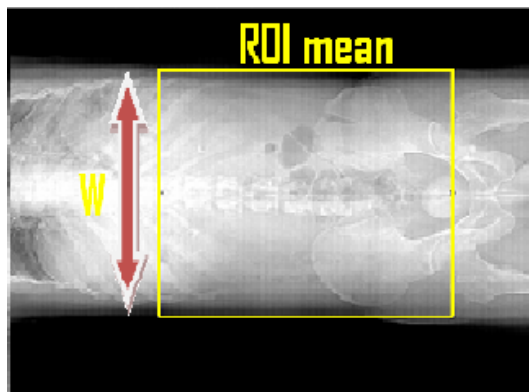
This figure shows the parameters which are used for scout attenuation area calculation. ROI mean is the average CT number of the pixels within the ROI and W is the average lateral width
